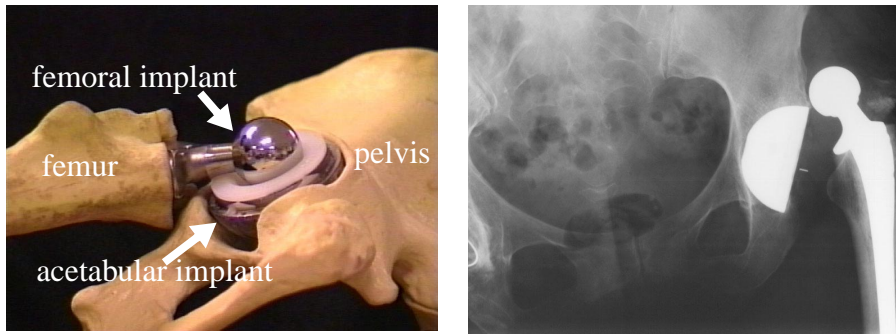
Femoral and acetabular implants in impingement, and X-Ray of dislocation.
